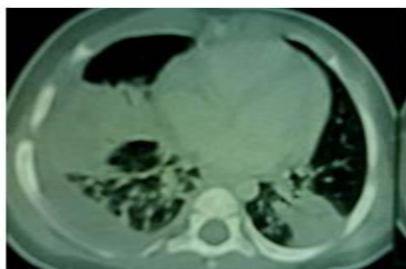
Axial contrast – enhanced CT scan of the chest on the left showing thickening, increased contrast uptake of the parietal pleura with loculated fluid and air in the pleural space
